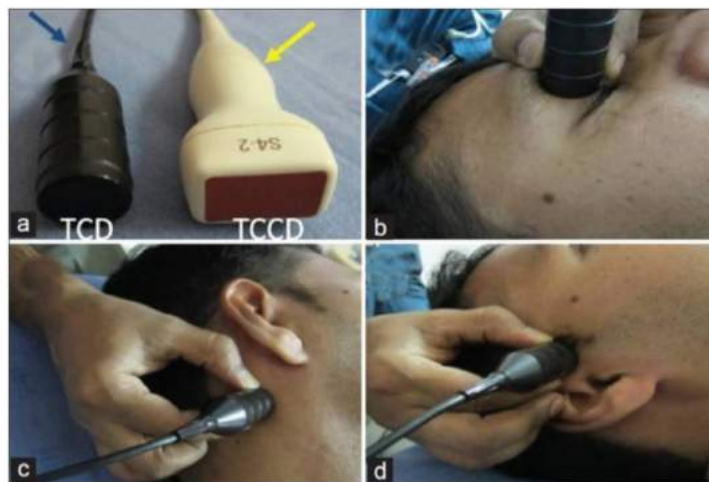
Transcranial Doppler probes and position
